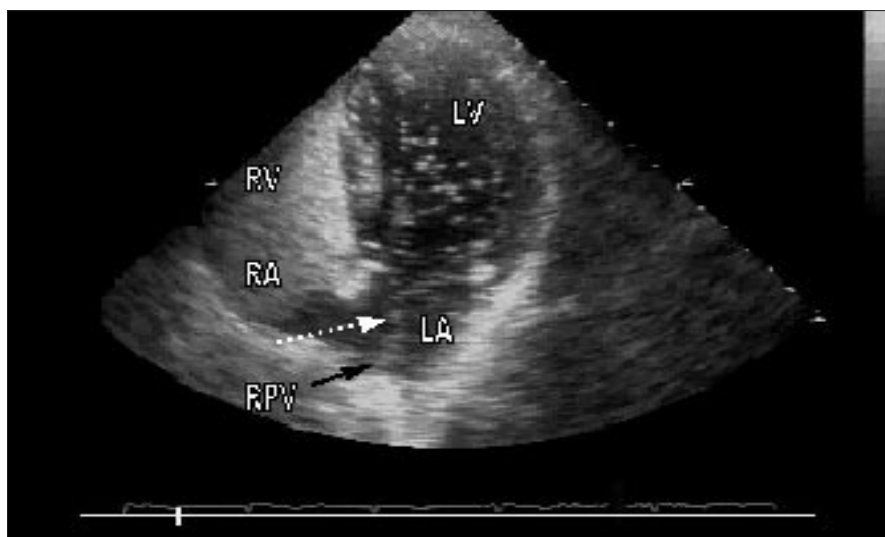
2-D echocardiogram (4-chamber view) using agitated saline air bubble contrast injected into an antecubital fossa vein. There is dense opacification of the right heart and a noticeable stream of contrast microcavitations (dashed arrow) from the right upper lobe pulmonary vein (bold arrow) through the left atrium dispersing into the left ventricle.
